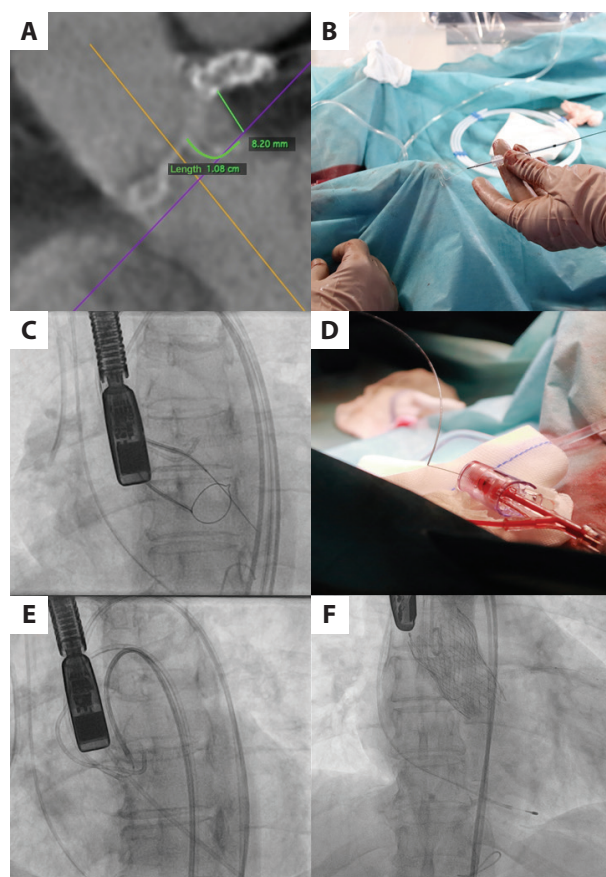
A. Computed tomography scan showing the left main artery take-off height of and leaflet length. B. A snare loop in left ventricular outflow tract. C. Wire retrieval. D. V-shaped wire. E. Snapshot of leaflet laceration sequence. F. Final outcome with a deployed valve and preserved coronary flow
